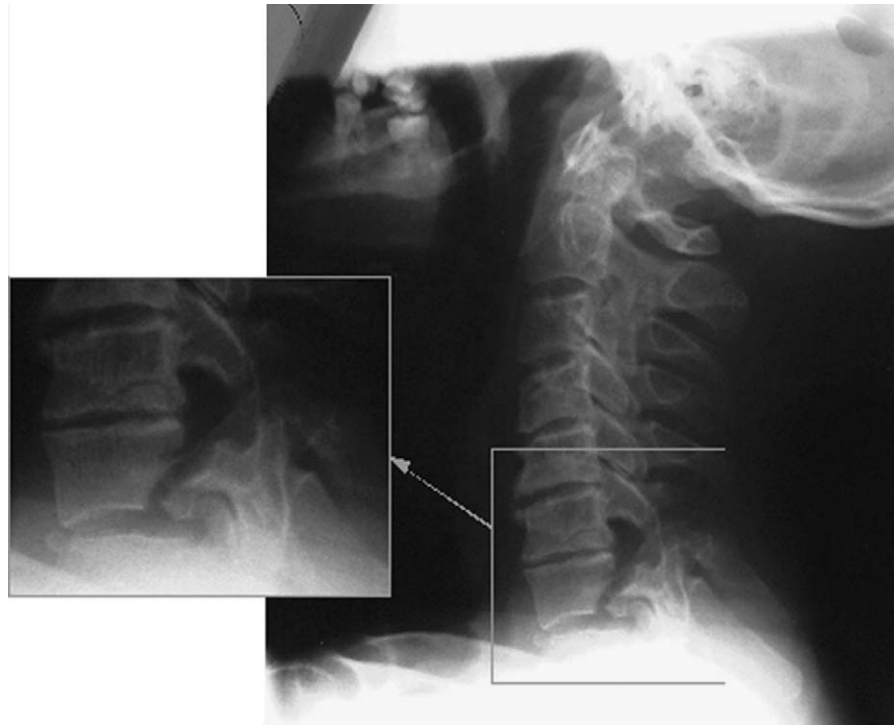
Plain lateral radiograph of cervical spine showing an oblique defect in the pars interarticularis of C7 vertebrae propagating anteriorly and inferiorly in to the superior aspect of the body of C7 vertebrae and C7-T1 disc and posteriorly and superiorly in to the C6 spinous process.
